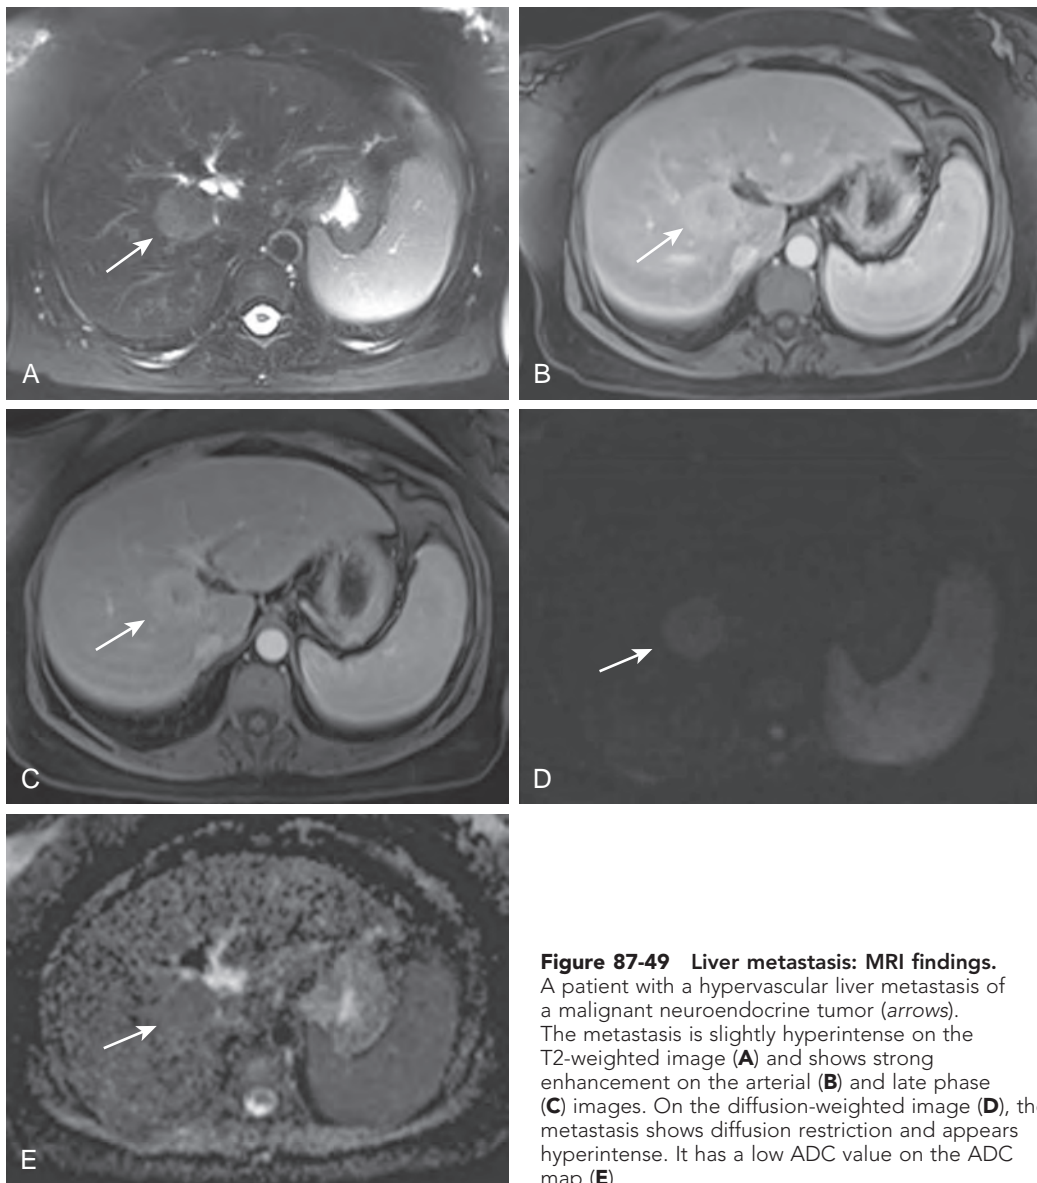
Liver metastasis: MRI findings.
